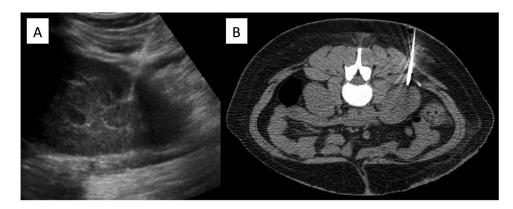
Biopsy needle insertion. (A) Ultrasound shows needle abutting kidney capsule with core track within kidney parenchyma. (B) Computed tomographic image shows trochar inserted and abutting kidney.
